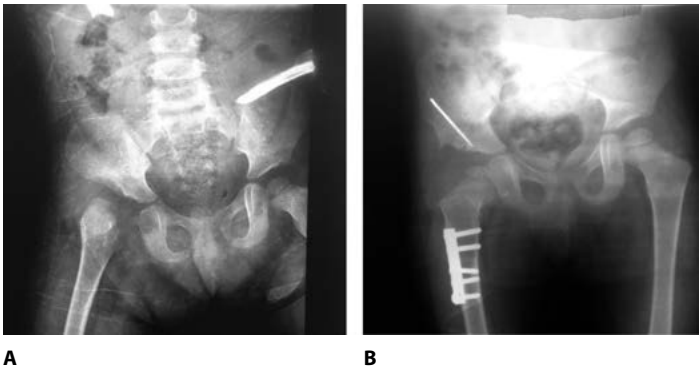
(A) Preoperative radiograph of 22 months old girl with right side DDH. (B) Same patient after 15 months follow-up of Modified salter osteotomy and femoral shortening
